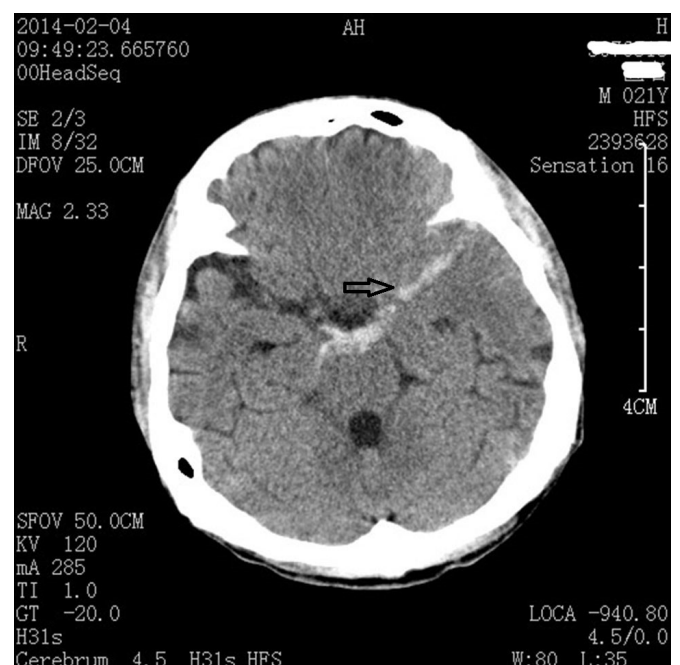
Head CT scan showed subarachnoid hemorrhage (arrow).
